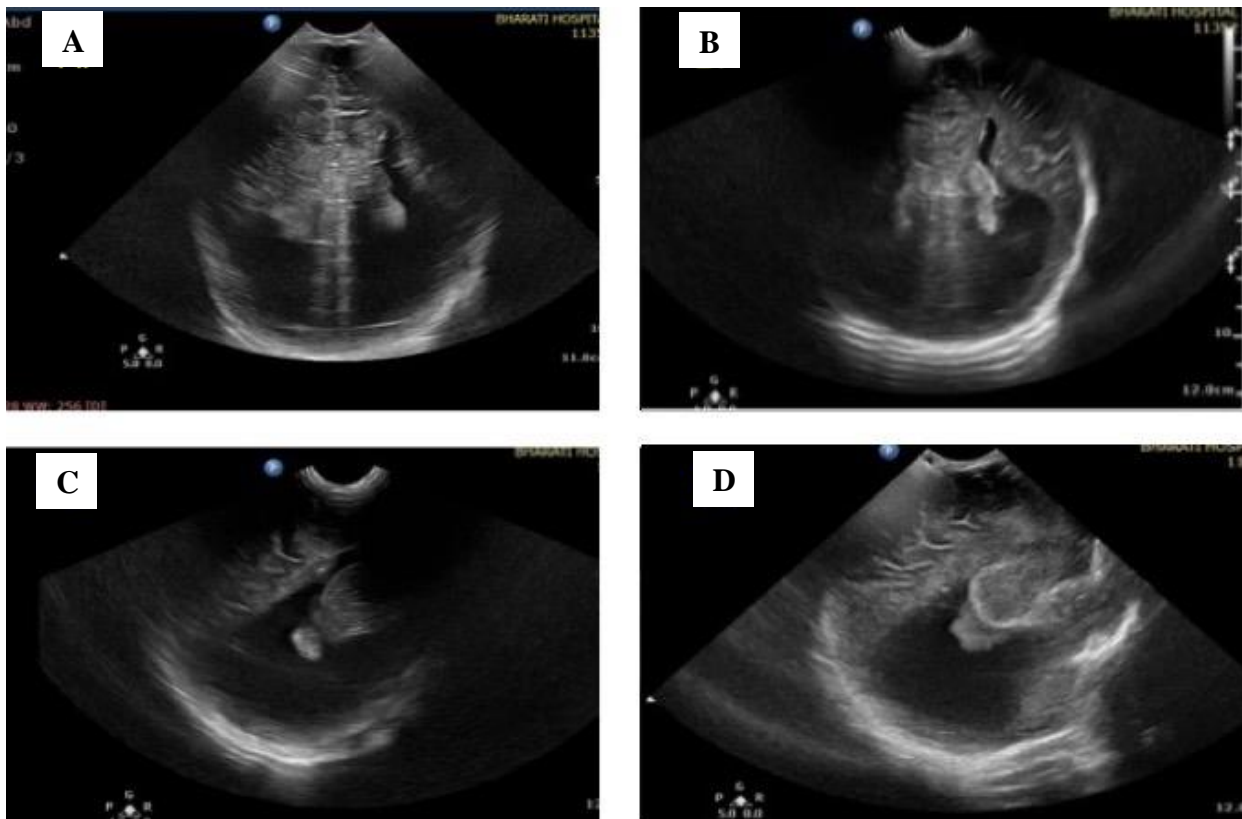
Neurosonography showing grade 3 intracranial haemorrhage. (A): Coronal section taken from anterior fontanella showing hyperechoic lesion within both lateral ventricles with dilatation of these ventricles, (B): Coronal section image taken from anterior fontanella at the level of frontal horns of lateral ventricles showing hyperechoic lesion in frontal horns of both lateral ventricles.
